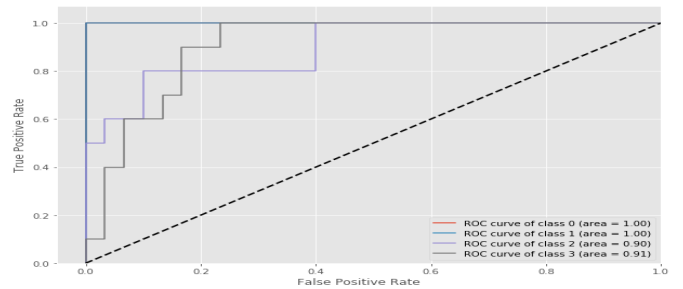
Receiver Operating Characteristic (ROC) Curve for the classification of COVID-19, bacterial pneumonia, viral pneumonia and normal X-ray images. Here, Class 0 - bacterial pneumonia, class 1 - COVID-19, class 2 - normal and class 3 - viral pneumonia
